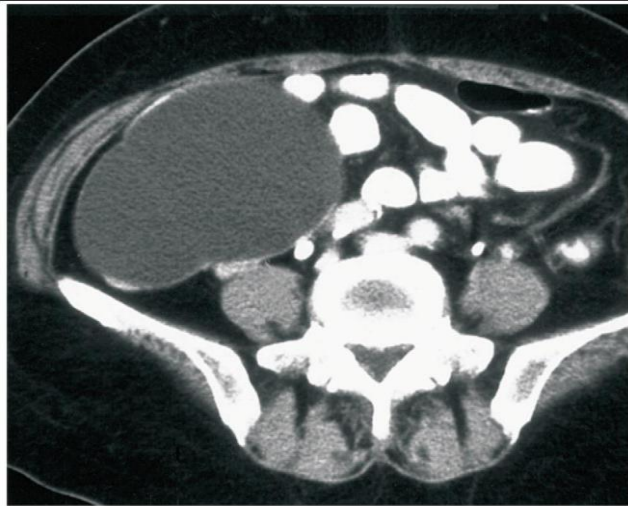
Figure Showing- 27 year old presented with irregular menstruation. Sonography revealed a large cystic area in the pelvis ovaries were not well visualized. CT Scan showed a unilocular right ovarian cyst
